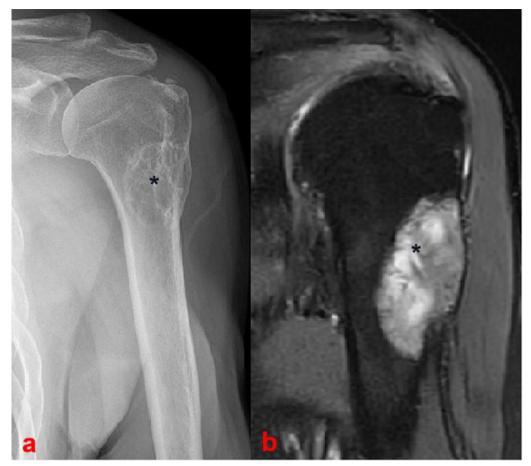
The radiographic images of fibrous dysplasia in Patient 5. A Preoperative anteroposterior X-ray showed a typical ground-glass appearance (black asterisk). B Preoperative coronal magnetic resonance imaging. The preoperative sagittal T2-weighted image showed multiple high intensities in the medullary space of humeri bone and a cystic lesion of the site (black asterisk)
